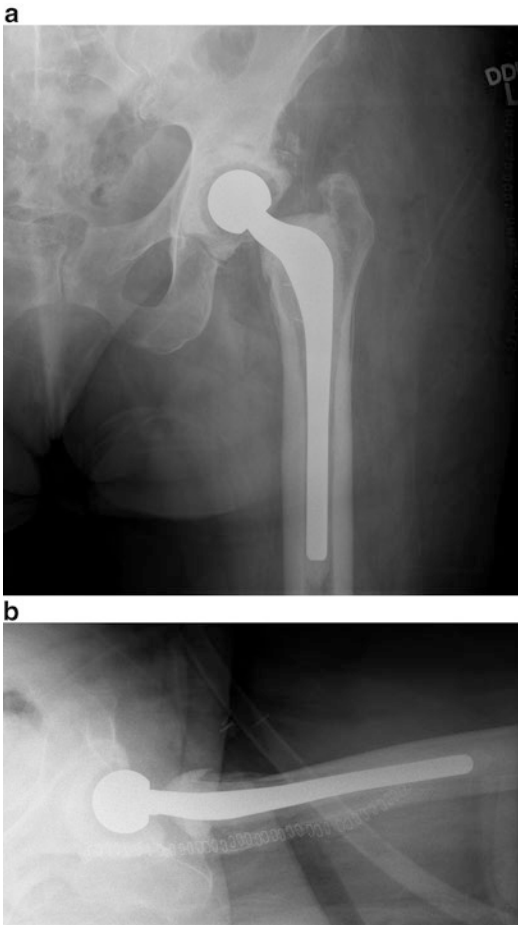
AP (a) and lateral (b) radiographs after resection of the implants and insertion of a PROSTALAC® (Depuy; Warsaw, IN) spacer for local antibiotic delivery. Note that cement has been placed around only the proximal portion of the femoral implant to facilitate removal at the time of reimplantation
